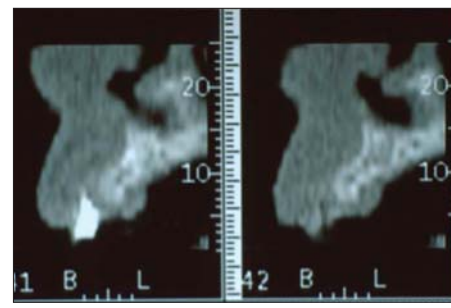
CT scan showing inadequate osseous volume faciolingually for implant placement.
